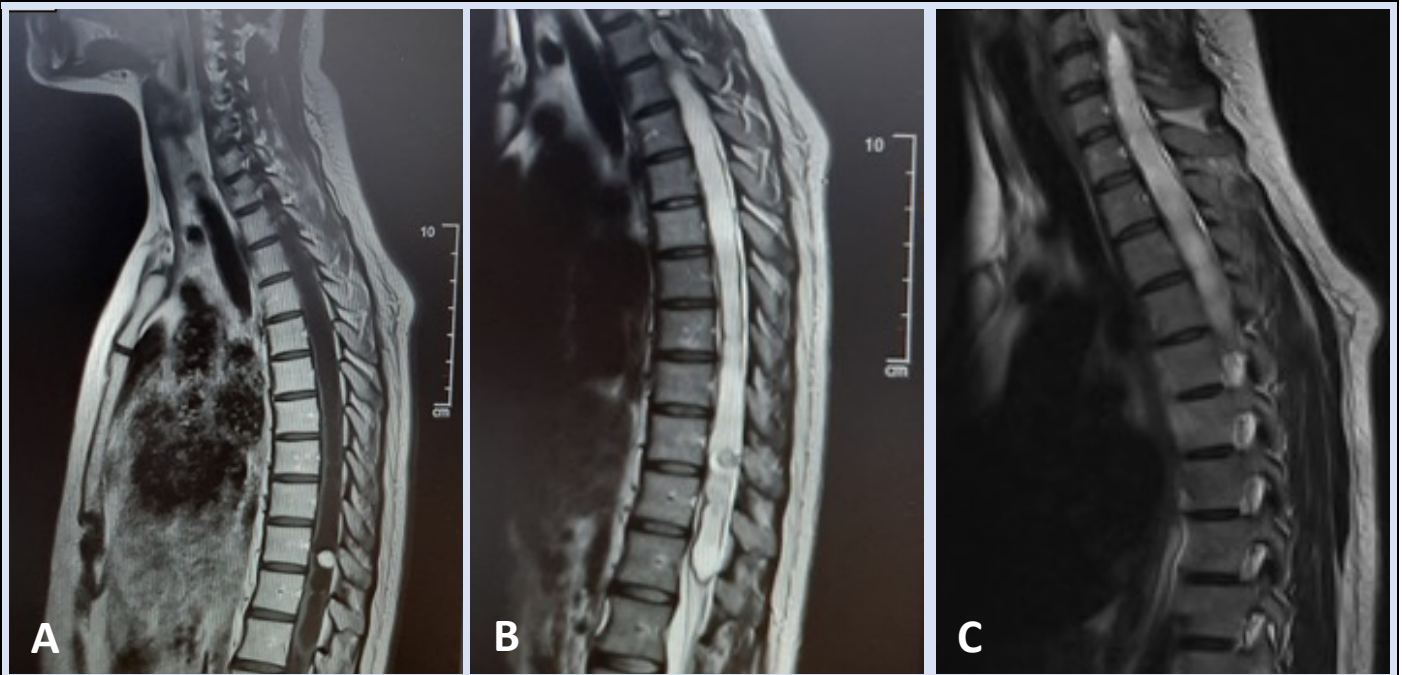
3D Preoperative whole spine MRI. Sagittal slices on T1 (image A) and sagittal slices on T2 (images B and C). They demonstrate the existence of a well-defined intramedullary nodule at the level of D10, hypointense on T2, hyperintense on T1 with intense contrast enhancement surrounding it. It associates a prominent syringomyelic cavities from C5-C6 above to D12 below, occupying almost the entire cord.
